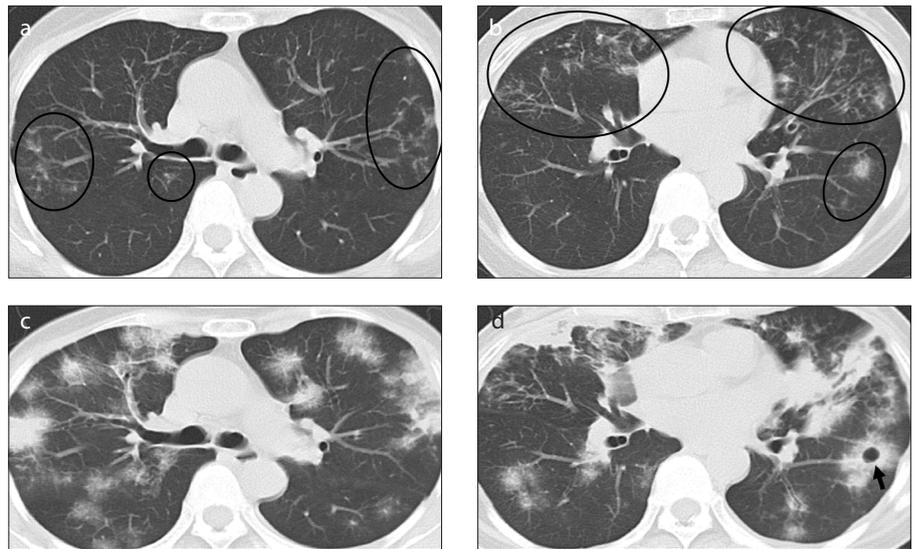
a–d. A 54-year-old woman with acute ATL. Initial chest CT images (a, b) show centrilobular opacities and pulmonary nodules in both lungs. Slight bronchiectasis and bronchial wall thickening are also seen (a, b, ovoid circles). Since mycobacterial infection was initially suspected, no workup for ATL was performed. Follow-up CT images (c, d) (without any treatment, three months after the initial scan) demonstrate multiple consolidations accompanied by ground-glass attenuation, which also forms a cavity in the left lower lobe (d, arrow). ATL was eventually confirmed by transbronchial lung biopsy.
